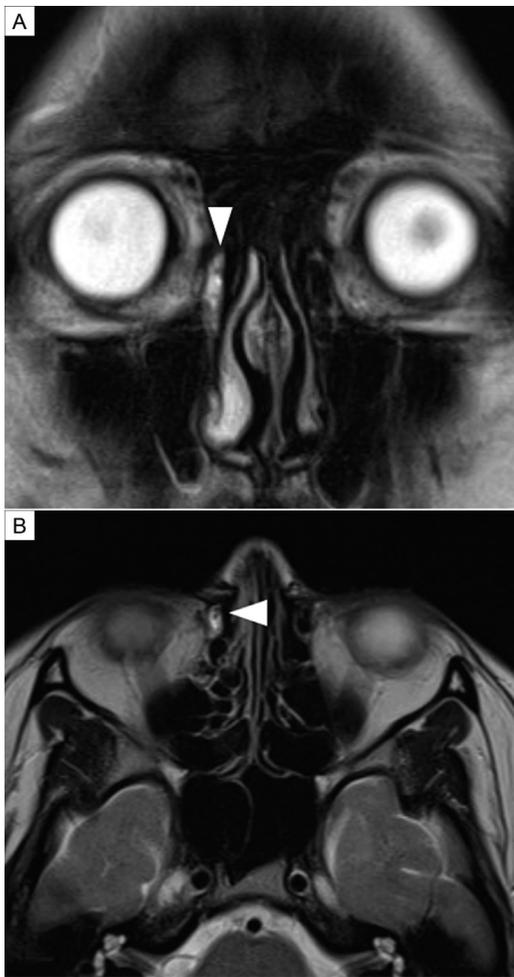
T2-weighted magnetic resonance imaging (MRI), coronal (A) and axial (B) slices, of patient 1 showing increased signal of right nasolacrimal duct (arrowheads).
